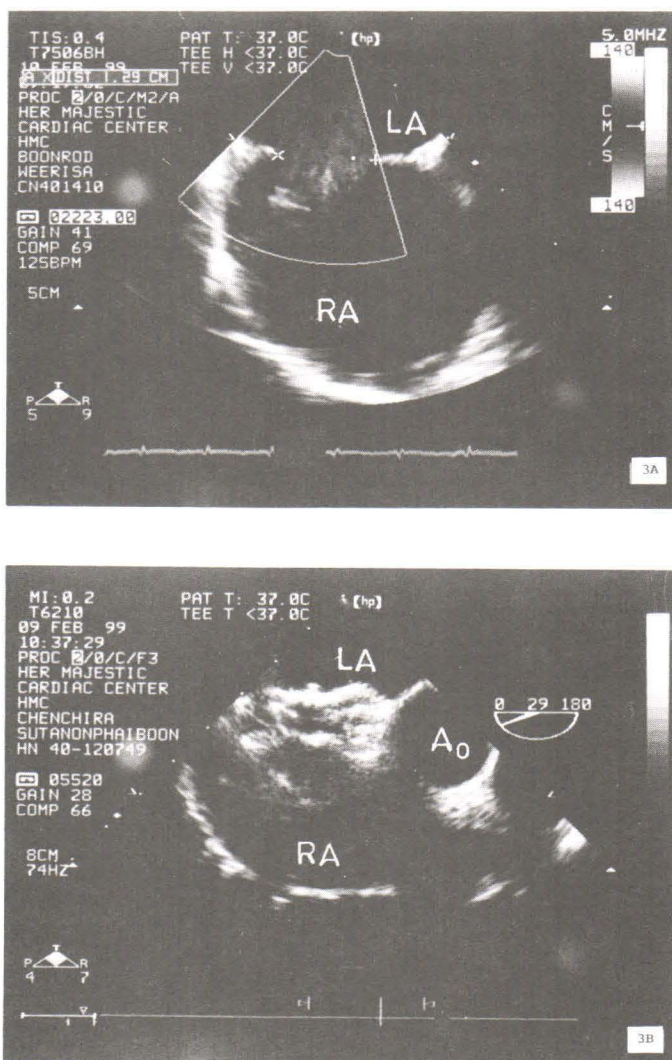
Transesophageal echocardiogram (TEE) short axis view showing the ASD before (3A) and after (3B) device placement: RA right atrium, LA left atrium, Ao aorta.
